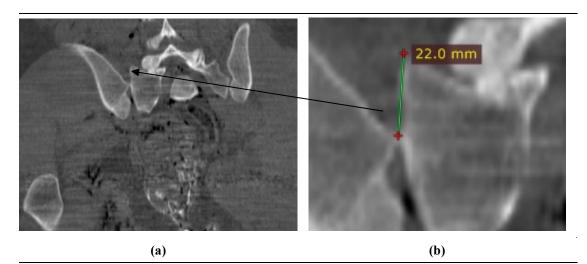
Measurement of anterior posterior displacement of the ilium (a) inferior displacement of the ilium in relation to the sacrum on CT (coronal view) (b) Zoomed image showing the measurement of the inferior displacement of -22mm.
